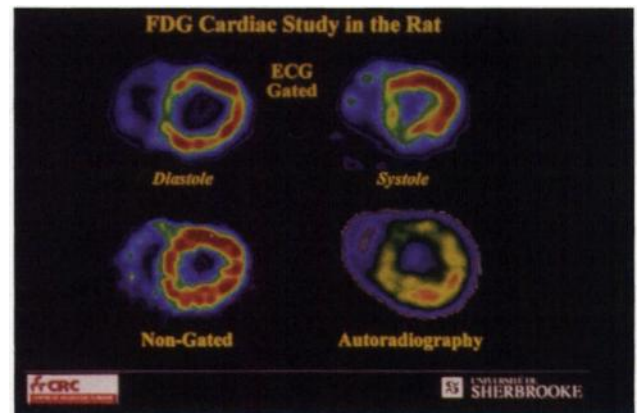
Gated and ungated images of cardiac metabolism with F-18 FDG.
